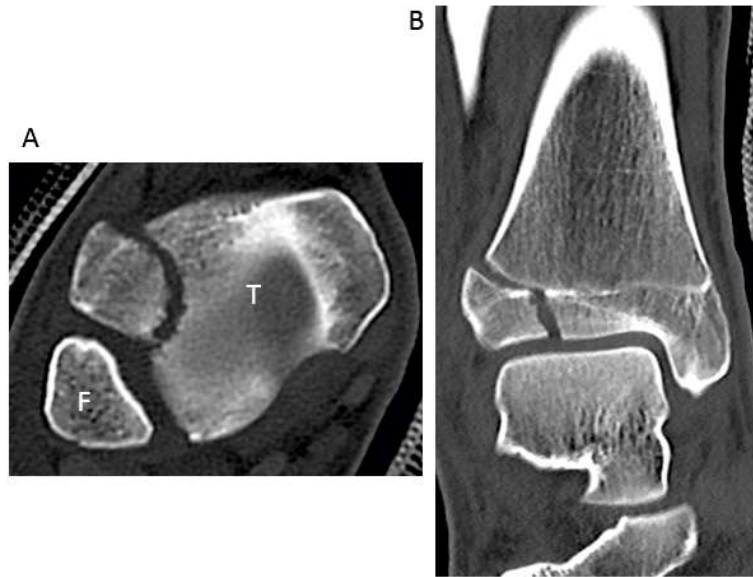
Axial (A) and coronal (B) CT scan images of an ankle demonstrating a Tillaux fracture injury pattern (T=tibia, F=fibula).
